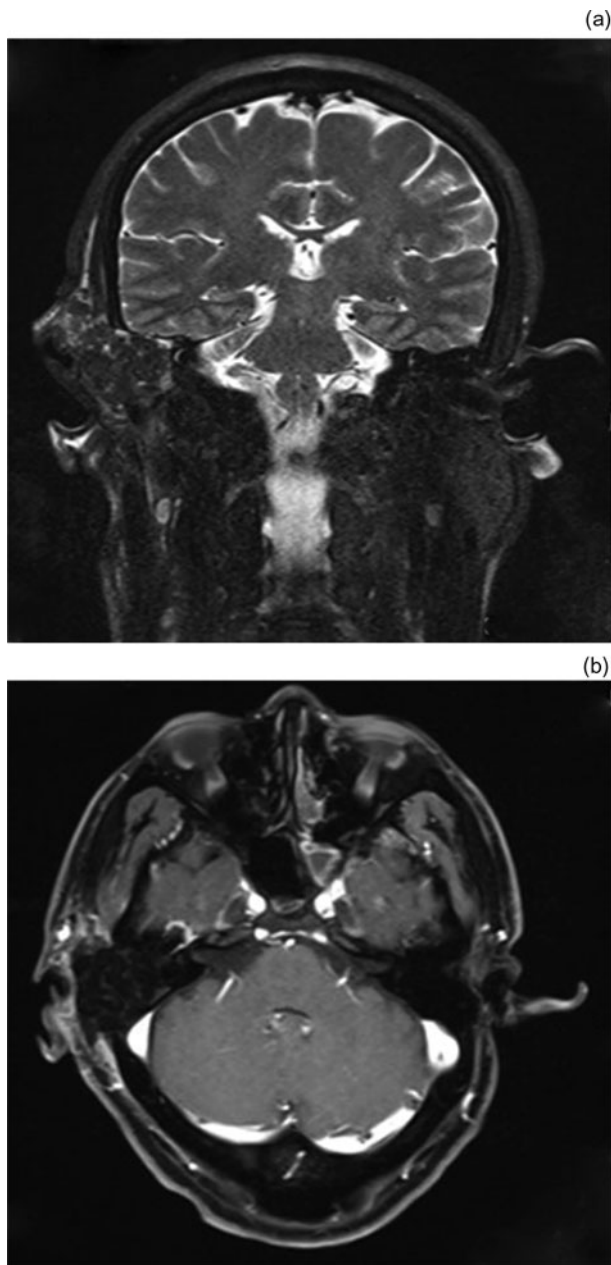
(a) Coronal T2-weighted magnetic resonance imaging (MRI) scan. (b) Axial T1-weighted MRI scan with contrast. The tumour was removed without residue.
